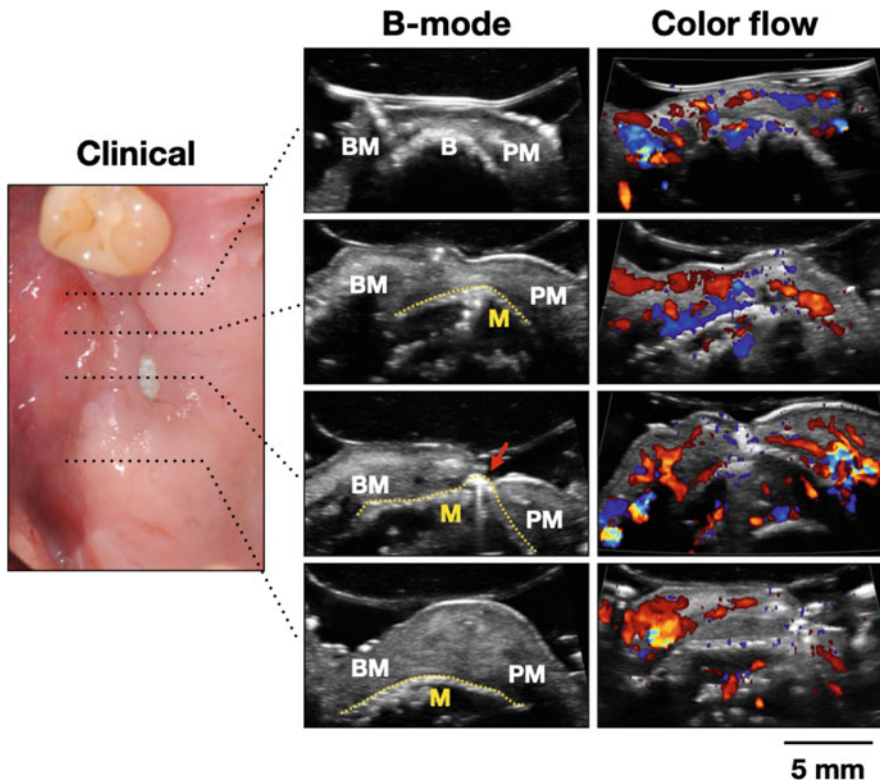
Ultrasound B-mode and color flow images of impaired GBR wound healing due to exposure of the non-resorbable membrane. Images were taken from the occlusal side. *M* membrane; *BM* buccal mucosa; *PM* palatal mucosa. Due to wound exposure and possible bacterial invasion, blood flow as seen on color flow images increases, an indicator of tissue inflammation
